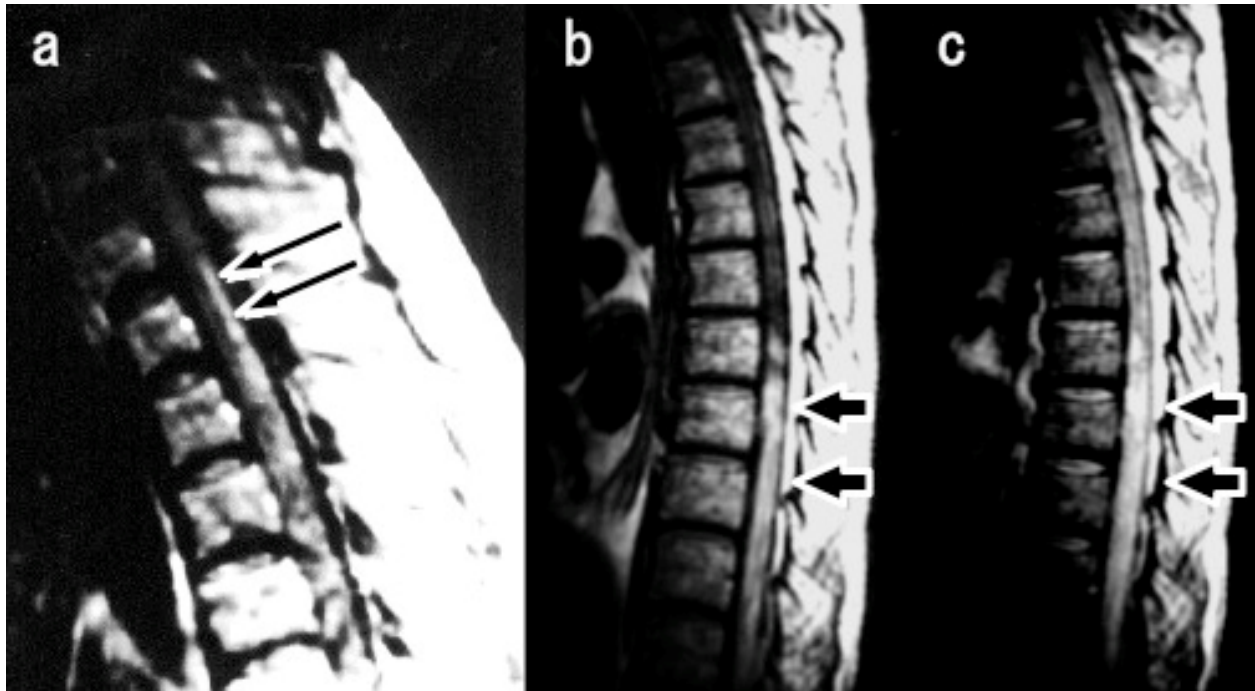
MRI findings of HSM. Enhanced T1-weighted imaging of HSM (HSV-2) showed an increased signal intensity in the posterior portion of spinal cord at the T2-T4 level (a). T1-weighted imaging (TE600/TR20) (b) and T2-weighted imaging (TE3,000/TR60) (c) of HSM (HSV-2). Both sequences showed a hyperintense signal lesion which was continuous from the T7 level to the lumbosacral spinal cord.
